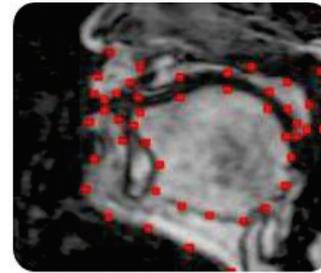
Feature points on MRI data.
